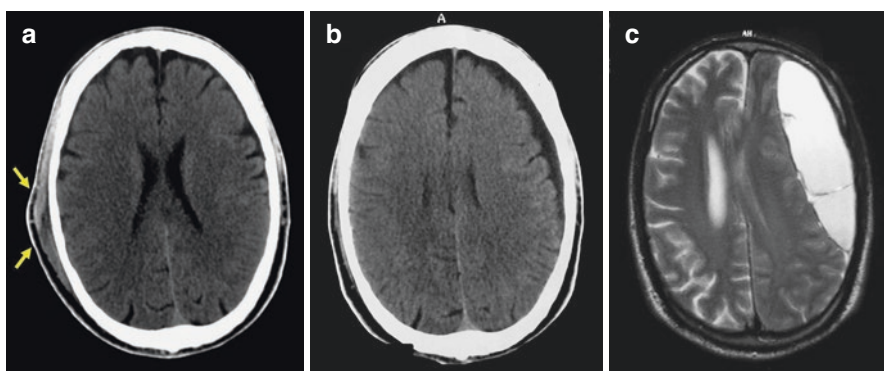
Case 4. Initial CT-scan in a 44-year-old man who sustained a head injury (a). There is no intracranial lesion but a scalp contusion was present on the right side (arrows) (a). Ten days later, a small left (contralateral) subdural hygroma can be seen (b). Two months from trauma, a voluminous chronic subdural hematoma was evident on T2-weighted MRI [on the opposite side of the initial trauma] (c)
